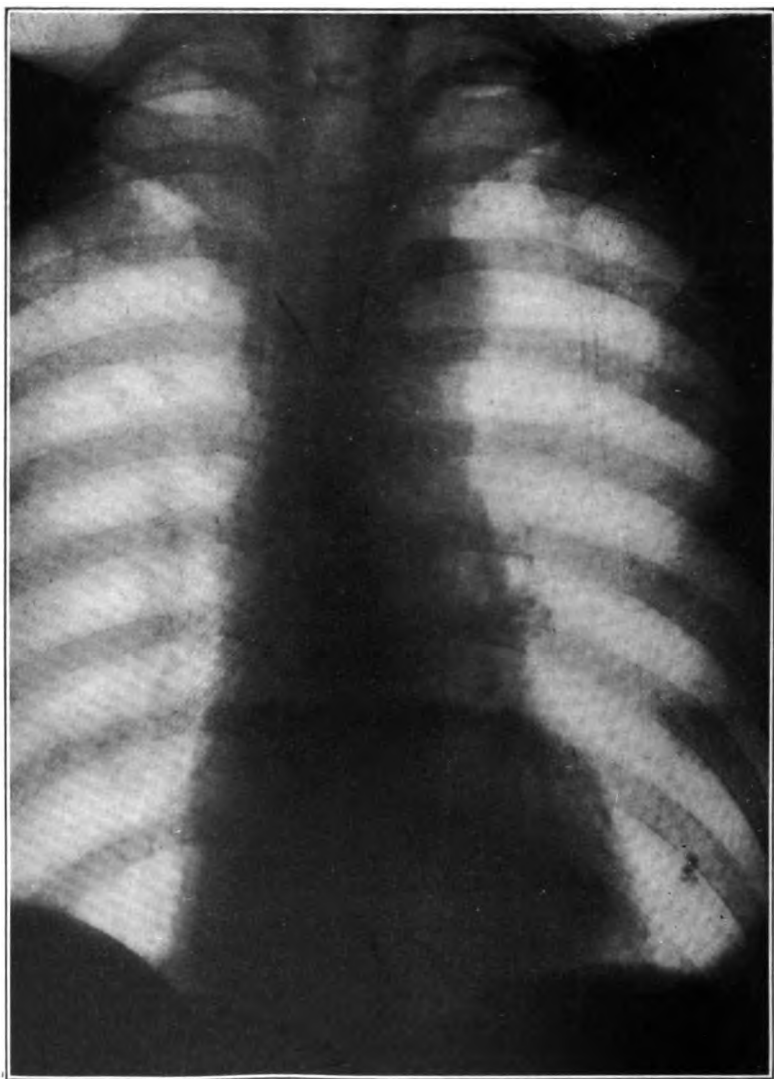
Roentgenogram showing a bit of wire from an egg beater in the esophagus, where it had lodged while the patient was eating custard pie. The hooked ends do not show because the bends are in the sagittal plane.
